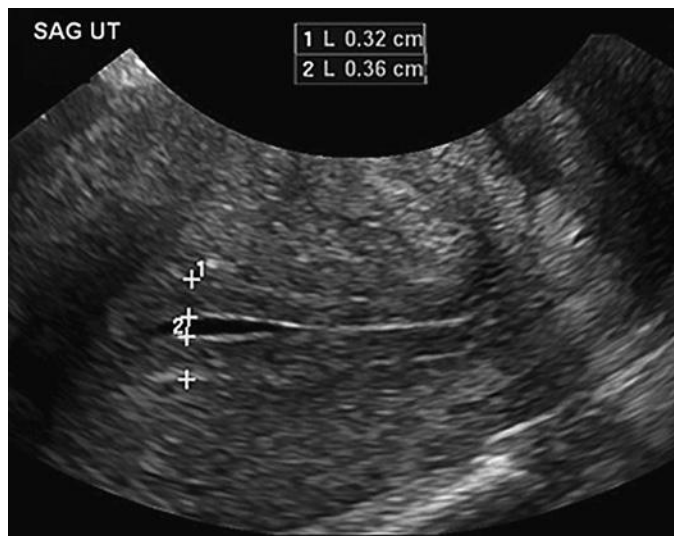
Normal ultrasound appearance of the endometrium during the periovulatory phase. Gray-scale transvaginal sagittal image of the uterus demonstrates the multilayered endometrium, with trace anechoic intrauterine fluid. The measurements of the anterior (1 calipers) and posterior (2 calipers) endometrial layers are summed, resulting in an endometrial thickness of 6.8 mm. The intracavitary fluid is not included in the measurement.
